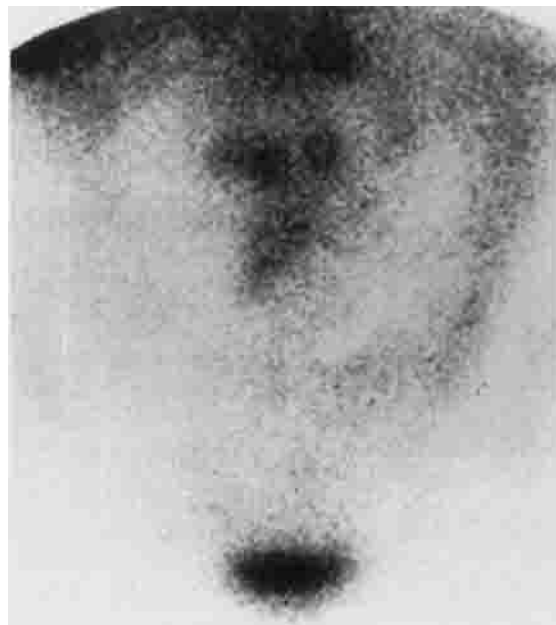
Case 1. Anterior scintigraphic image 48 hr after intravenous infusion of In-111-DTPA-B72.3 mAb. It demonstrates multiple foci of activity in the retroperitoneal area suggesting metastatic tumor. No tumor was found here at surgery or in the excised lymph nodes.
